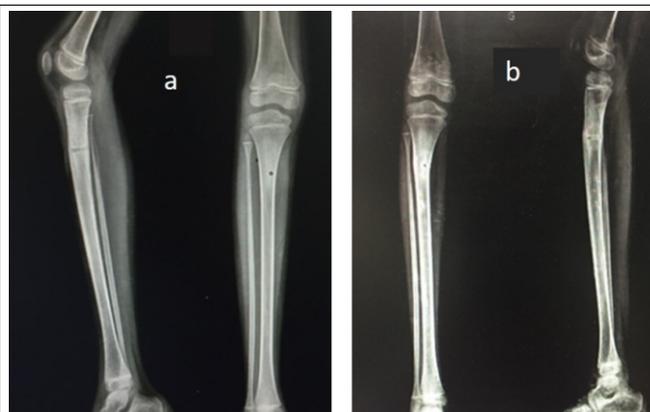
(a) Radiograph showing complication of proximal tibia fracture at radiofrequency ablation site following a fall. (b) Fracture union with cast immobilization.
